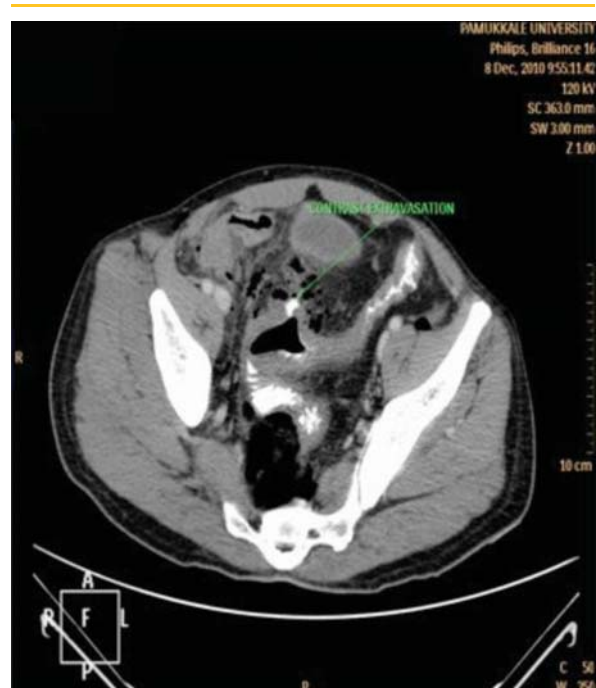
CT demonstrate late perforation.
